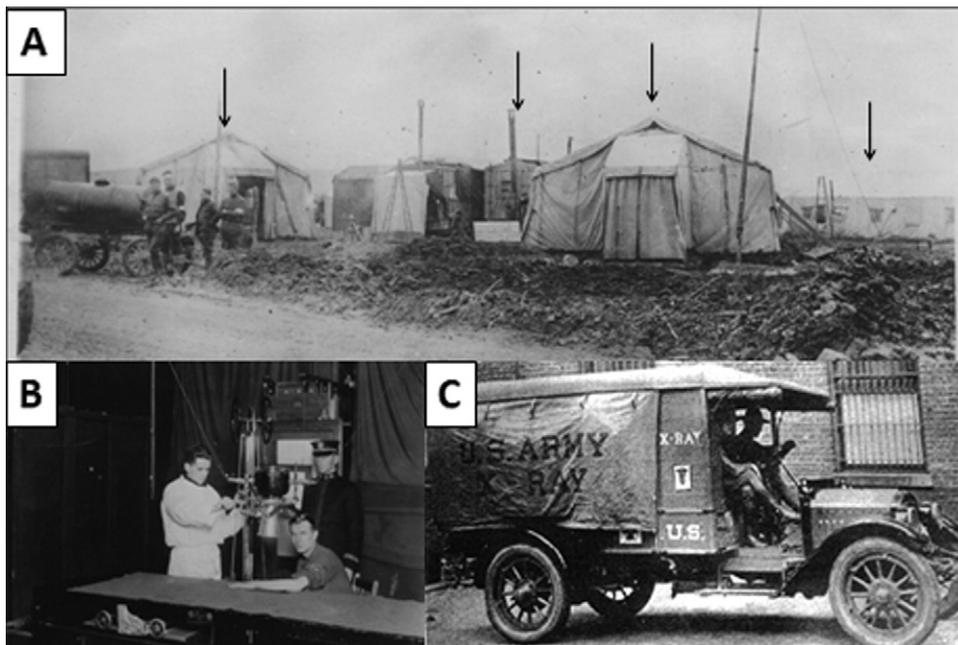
(A) Military hospital (1914-1918) with radiology station. Mobile Hospital No. 6, Varennes Station, France. Structures shown left to right (arrows): evacuation ward, radiology station, shock tent, postoperative ward. (B) US Naval Hospital No. 1, Brest, France (1914-1918) during World War I; personnel configuring x-ray equipment. (C) US Military Mobile X-Ray Unit, World War I. Source: National Museum of Health and Medicine, Armed Forces Institute of Pathology, Washington, DC.
